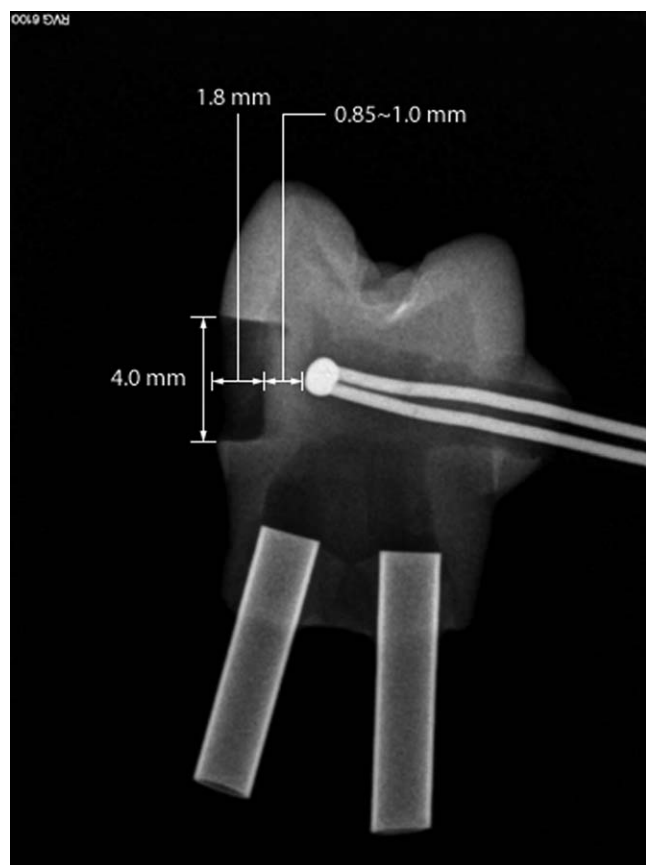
X-ray of the prepared premolar with a thermocouple and metal tubes.
